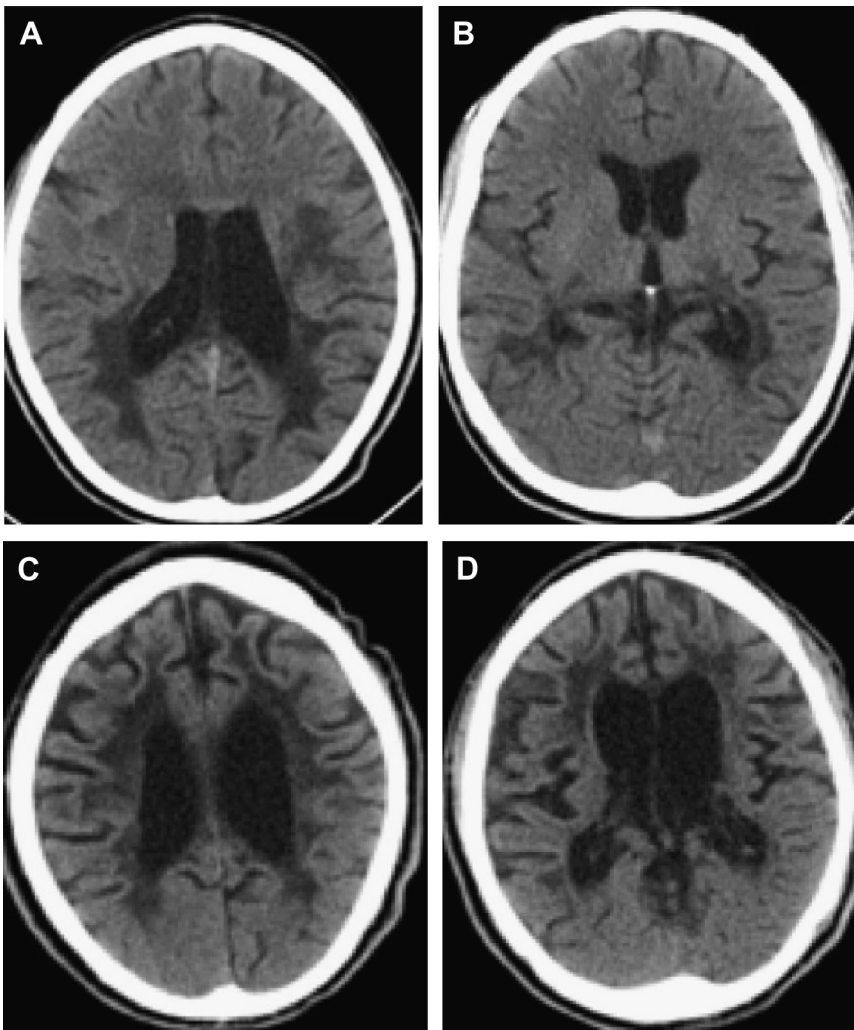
Progressive white matter changes from X-linked adrenoleukodystrophy at 15 (A, B) and 21 (C, D) years of age. The classic involvement of the splenium and parietooccipital white matter is obvious on the initial computed tomography study. By the follow-up study, there is nonspecific end-stage white matter disease with volume loss and diffuse hypodensity of the cerebral white matter.
